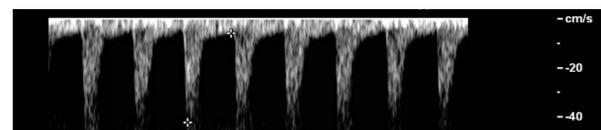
Doppler on day 6 after biopsy with complete normalization of the spectral flow pattern.
